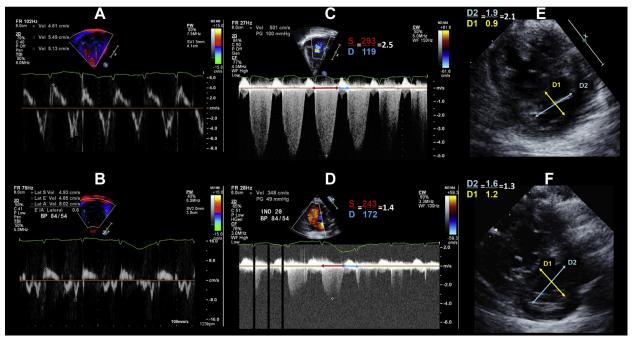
Echocardiographic measurements before and after vasodilator testing. RV Doppler tissue imaging before (A) and after (B) testing, tricuspid regurgitation jet with systolic to diastolic ratio before (C) and after (D) testing, eccentricity index before (E) and after (F) testing. Measurements were obtained before and after testing, with averaging over three consecutive beats.
